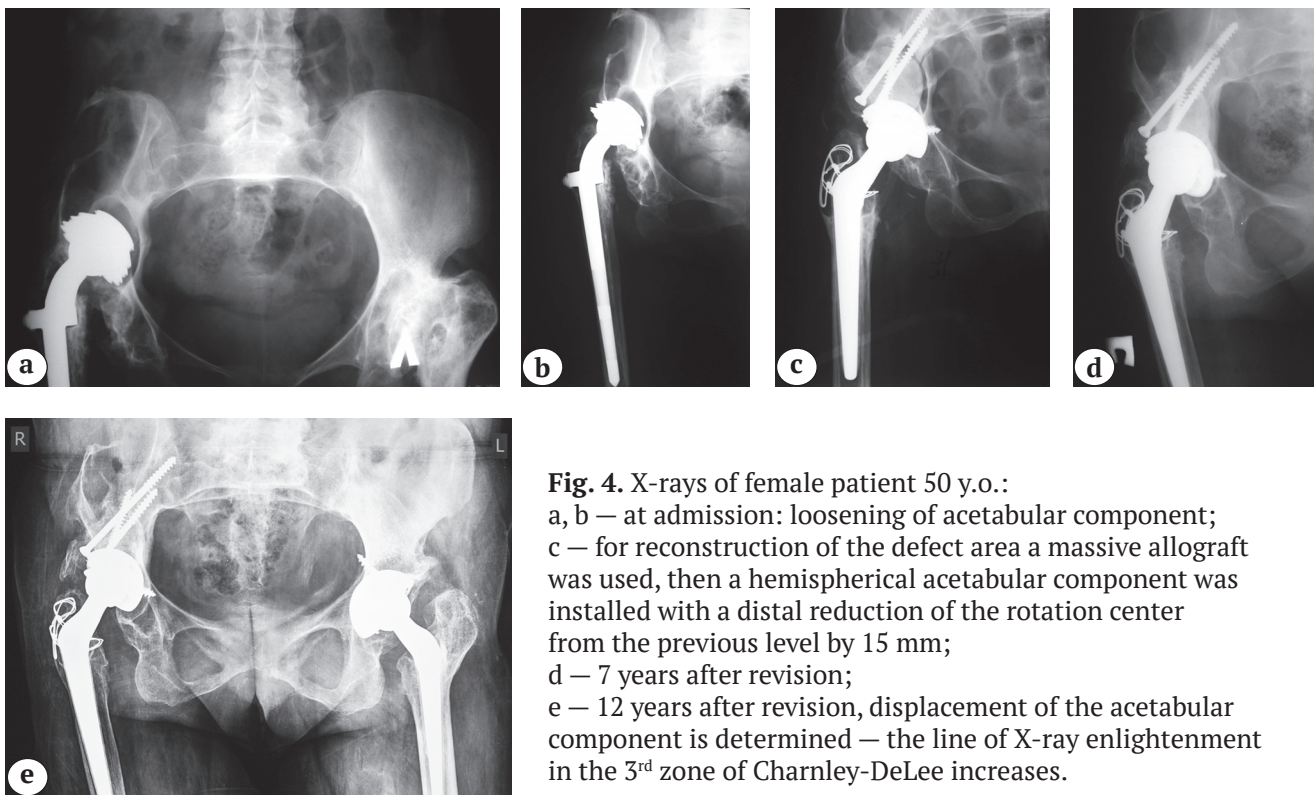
X-rays of female patient 50 y.o.:
